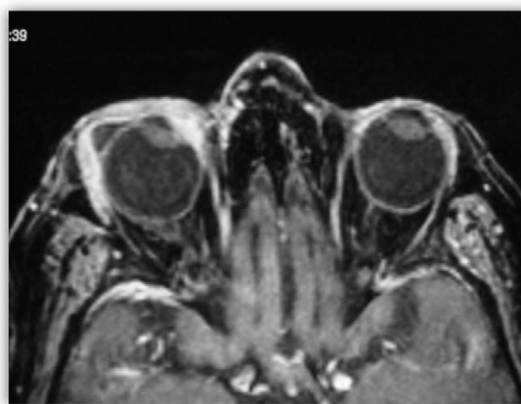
Magnetic resonance imaging of the right orbit showing globe invasion by the tumor.
